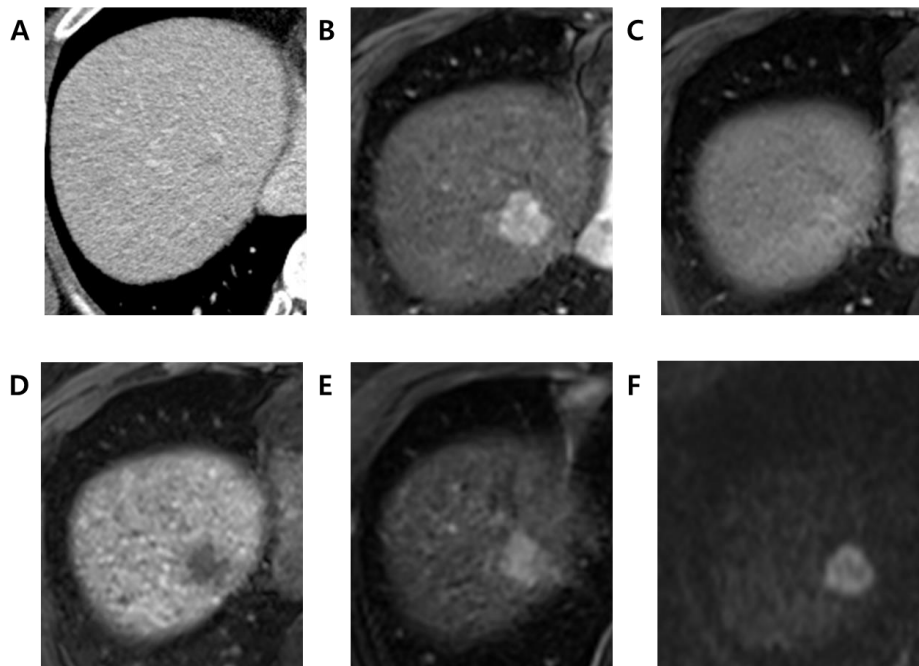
34 year-old man with combined hepatocellular-cholangiocarcinoma. (A) Portal venous phase of abdominal CT taken on December 27th, 2008 shows focal hypodense lesion measuring less than 1cm in longest diameter. Gadoxetate enhanced MRI taken on June 7th, 2009 (about six months later from prior exam) with (B) late
